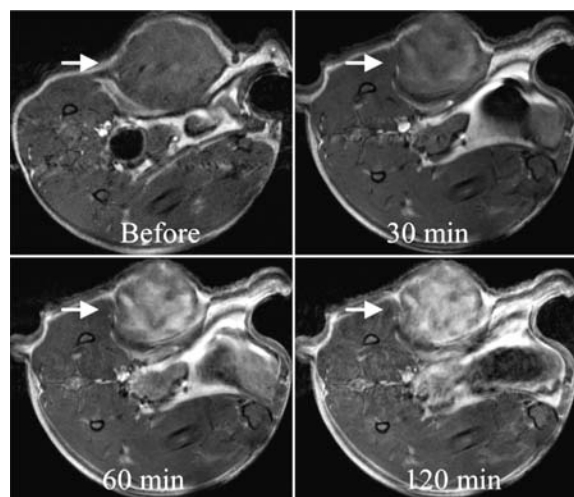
A time course of the *in vivo* tumor MRI imaging following i.v. injection of the probe Tf^{NR}-Lip^{NBD}-CA. The images show gradually increased enhancement of the tumor signals (arrow) and heterogeneous enhancement pattern within the tumor. The MRI parameters are TE=11.416 ms, TR=800 ms, number of average=4, field of view=(28×30) mm², matrix size=256×192, and slice thickness=1.0 mm
